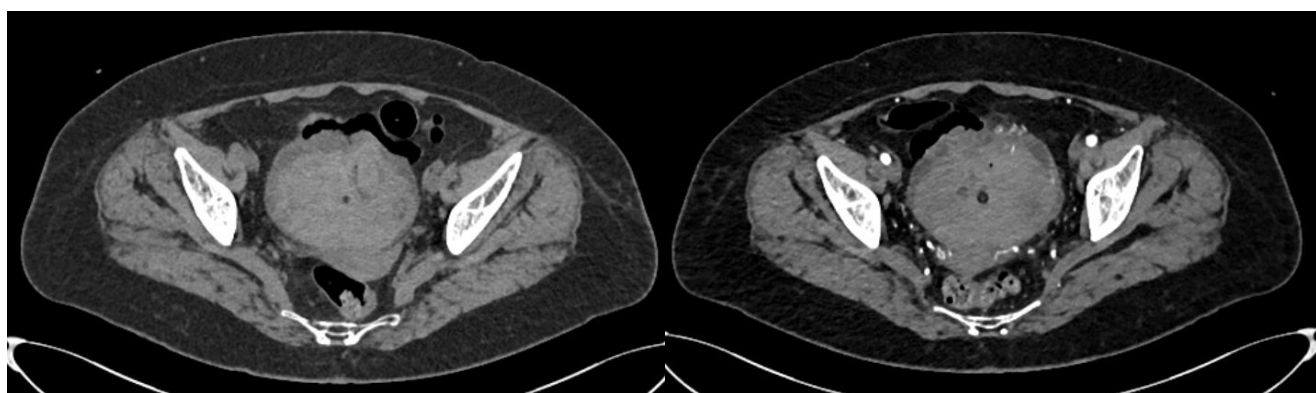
Computed tomography of the abdomen shows mural irregularity and air foci along the anterior wall of urinary bladder with prominent vascularity.
